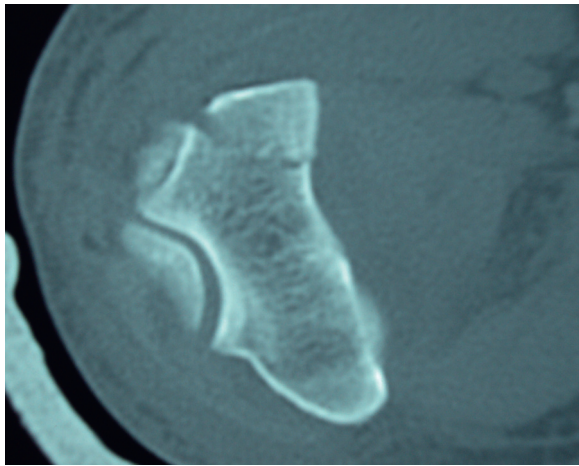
CT showing trochlear fracture in coronal plane.
